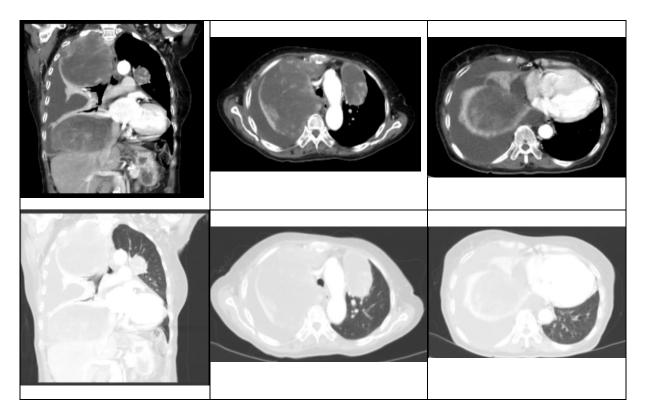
Patient's CT Scan IV Contrast on 06/06/2024. Post-contrast imaging revealed a heterogeneous, enhancing lobulated mass in the right and left lungs, predominantly on the right, measuring approximately $3.0 \times 3.7 \times 7.4 \text{ cm}$ to $13.0 \times 13.0 \times 10.0 \text{ cm}$. Total atelectasis of the right lung was noted. There was a right pleural effusion with a nodule in the posterior right pleura, measuring approximately $3.0 \times 2.0 \text{ cm}$. Multiple hypodense lesions, several millimeters in size, were observed in the liver and spleen. Additionally, a nodule measuring approximately 1.4 cm was identified in the subcutaneous tissue of the left anterior chest wall. The mediastinal structures appeared unremarkable, and the right and left main bronchi were patent. There was no cardiac enlargement or evidence of pericardial effusion. There was no enlargement of the mediastinal or hilar lymph nodes. The bones appeared normal, and no suprarenal nodules were identified.
